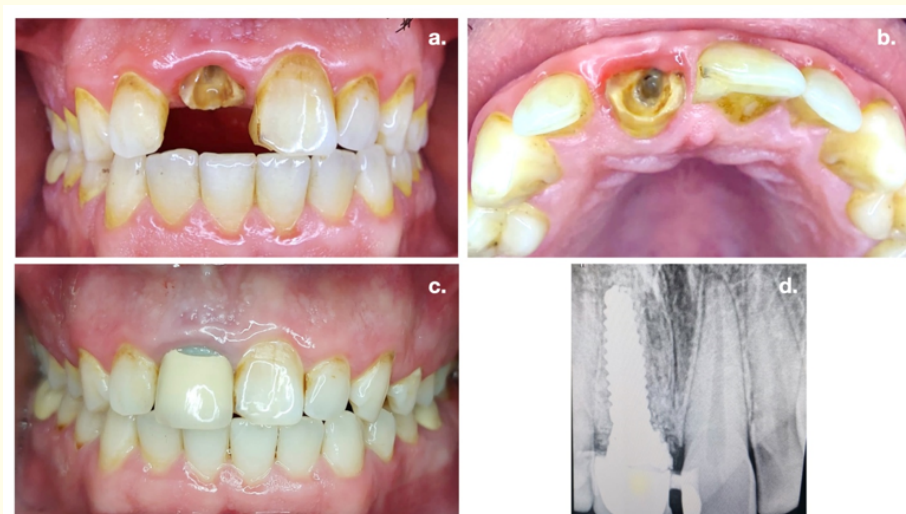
Dental implant placement: (a) Frontal view of a non-restorable right maxillary central incisor. (b) Occlusal view of the non-restorable right maxillary central incisor. (c) Frontal view of the area after tooth fragment extraction and implant placement with immediate temporization using the patient old crown. (d) Periapical radiograph showing the implant placement
